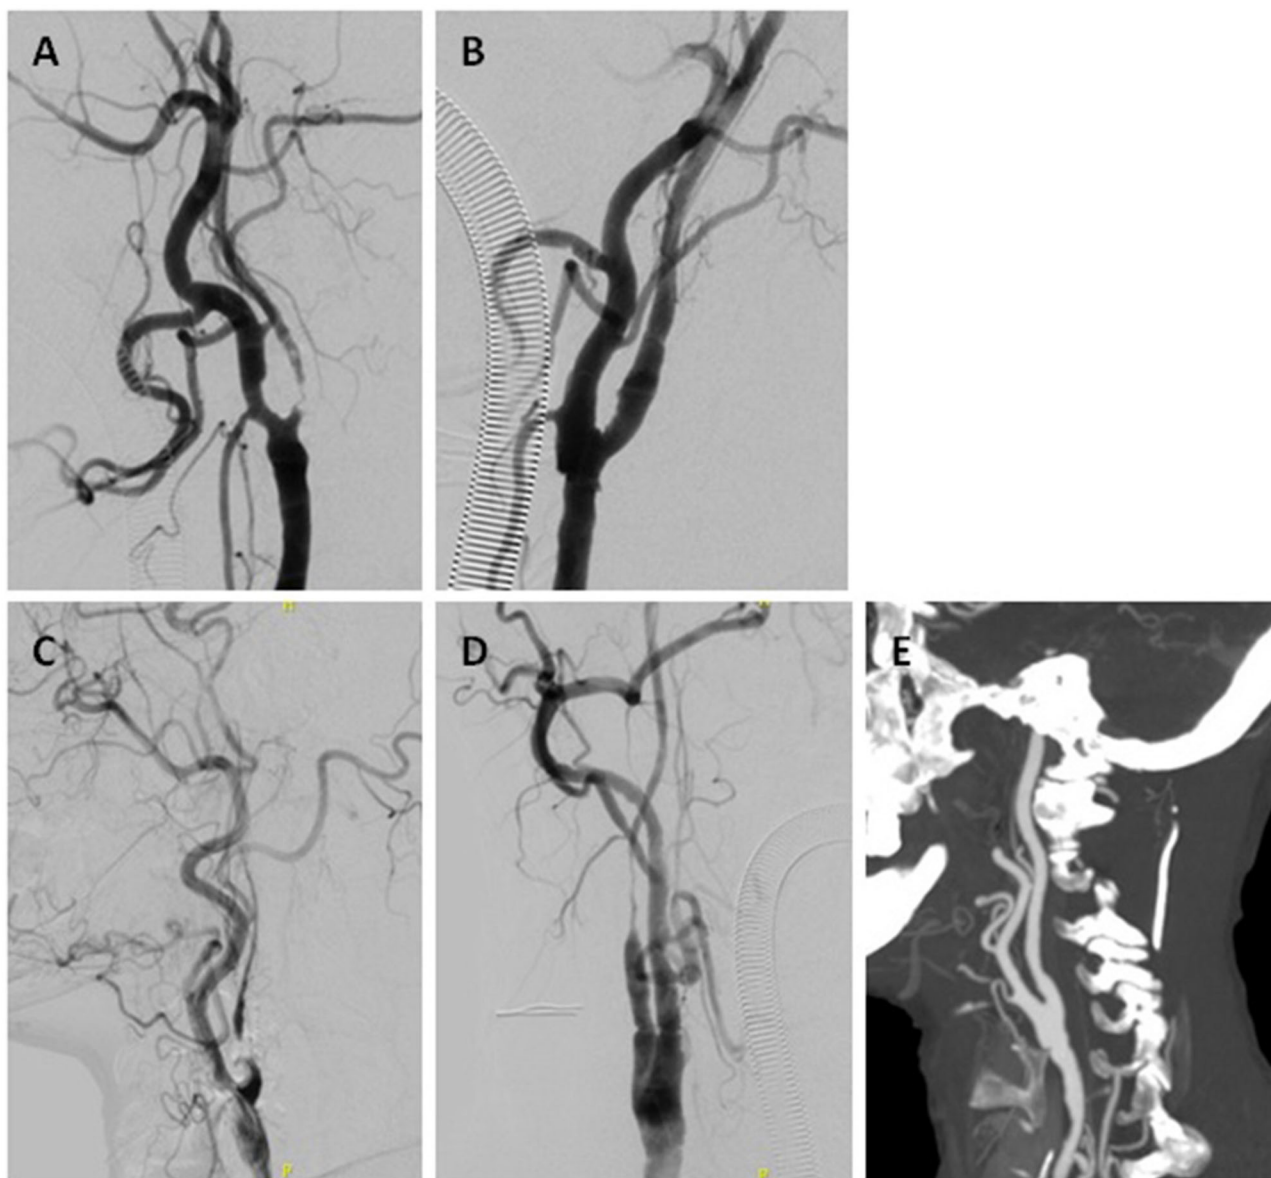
Two cases of ICANO with hybrid recanalization. Case-1 (A,B) A 66-year-old woman complaining of TIA 2 months was hospitalized. (A) Digital subtraction angiogram (DSA) before the hybrid surgery revealed a left ICANO. (B) Immediate angiogram of the left ICA after recanalization showed distal-dilatation. CASE-2 (C-E) A 71-year-old man complaining of glossolalia and left limbs weakness 20 days was hospitalized. (C) Preoperative DSA revealed a right ICANO. (D) Immediate angiogram of right ICA after recanalization showed distal-narrowness. (E) Computed tomography angiogram (CTA) performed 1 week postoperatively showed dilated right ICA.
